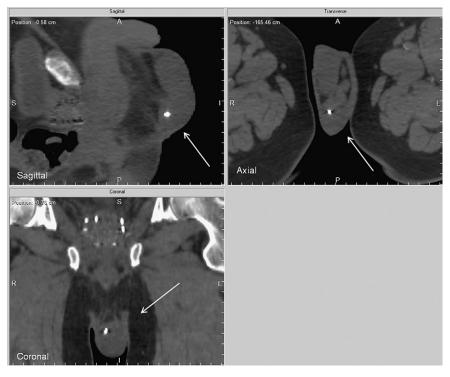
One month after seed implantation, pelvic computed tomography shows that a seed migrated to the left side of the scrotum (arrows).
